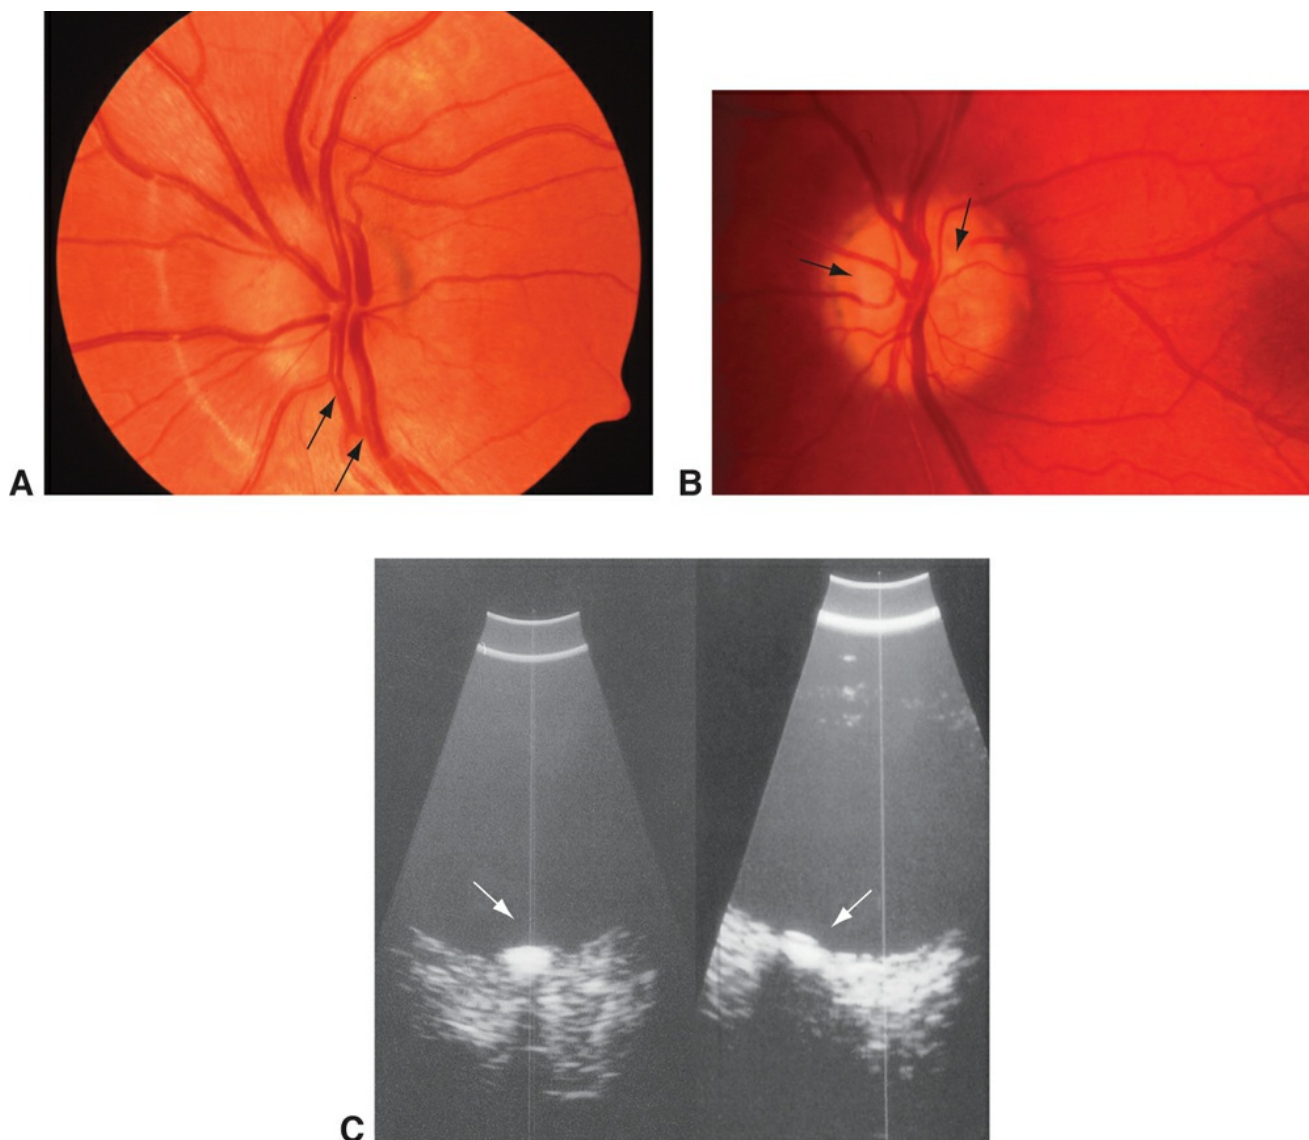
A, Pseudopapilledema. There is anomalous branching (*arrows*) of the large retinal vessels without disc hyperemia, retinal hemorrhages, or exudates. B, Optic disc drusen seen as refractile opacities on the disc surface (*arrows*). C, Ultrasonographic image shows a bright spot in the optic disc (*arrows*), consistent with drusen. (*Parts A and B courtesy of Paul Phillips, MD; part C courtesy of Edward G. Buckley, MD.*)
